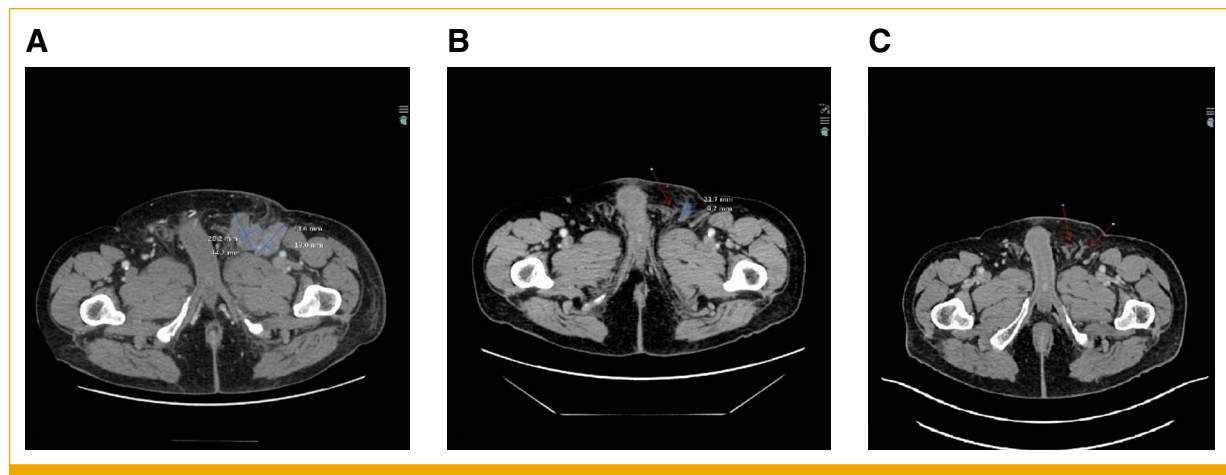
Contrast-enhanced axial CT scans of the pelvic area. (A) Baseline, showing enlarged pathologic lymph nodes in the left inguinal region. (B) After three cycles of treatment, showing partial regression. (C) After nine cycles of treatment, showing complete regression of lymph node metastases. CT, computed tomography.
